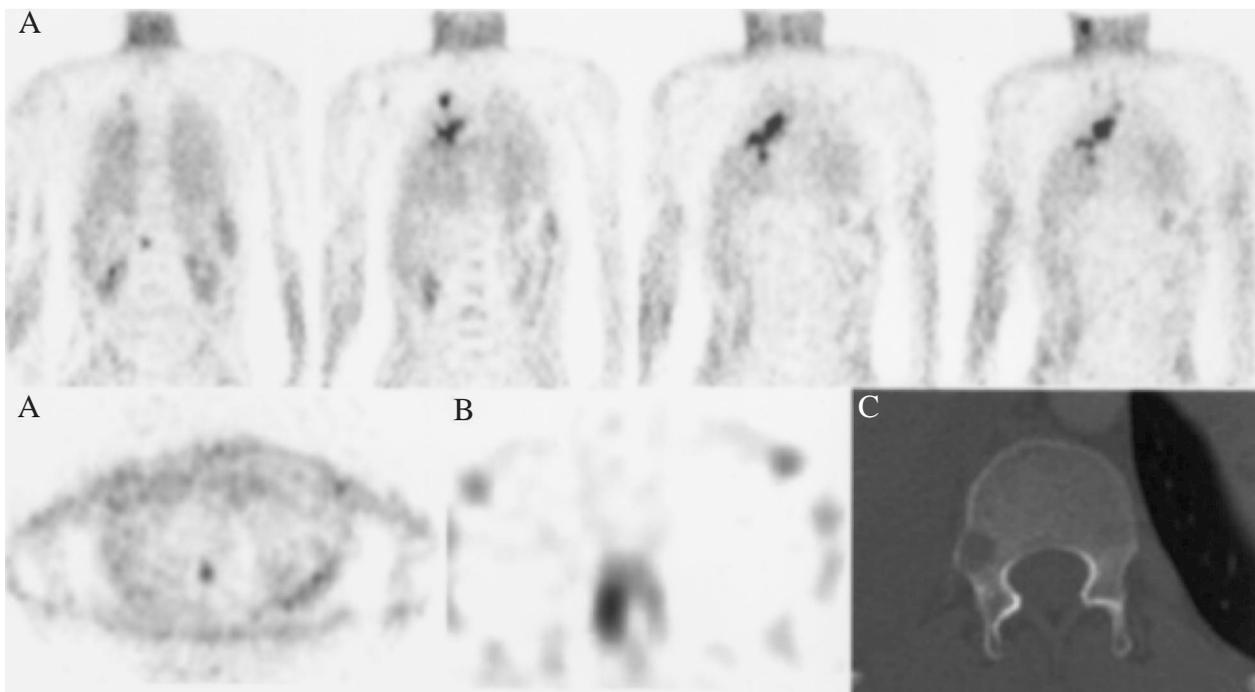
Hybrid fluorodeoxyglucose positron emission tomography (FDG PET) (A) of a 39-year-old male patient with adenocarcinoma of the apical right lobe of the lung with extensive metastatic involvement of peribronchial, hilar, central mediastinal and cervical lymph nodes. A small metastasis to the right pedicle of 12th thoracic vertebra (panel C: computed tomography in bone window; diameter of the lytic lesion 1.1 cm) shows good demarcation with hybrid PET and bone scintigraphy single photon emission computed tomography (B) as well.
